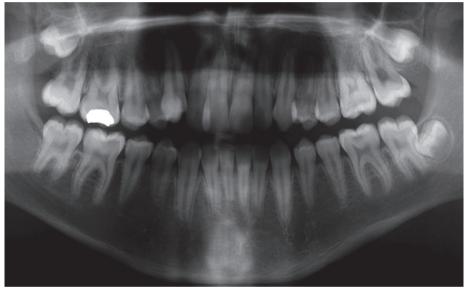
Panoral radiograph. Note the peri-apical pathology associated with the UR6.
